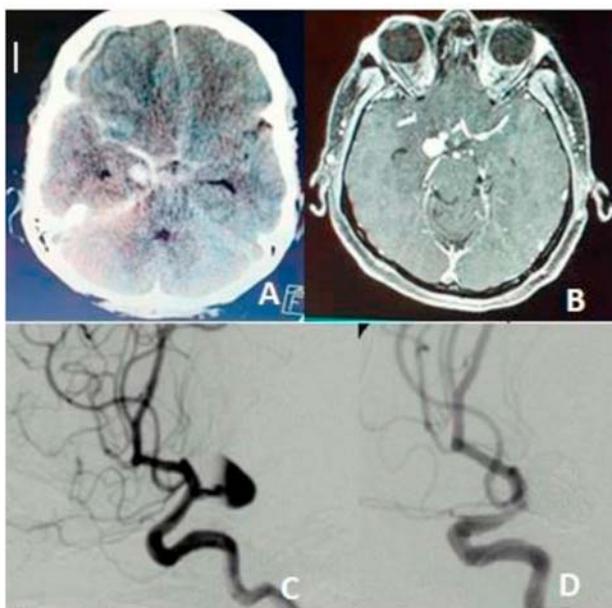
(A) Cranial CT with right pontine hemorrhage and aSDH. (B) Cranial MRI angiography that shows the right pontine saccular image. Aneurysm of the communicating segment of the internal carotid artery before (C) and after coiling (D).
